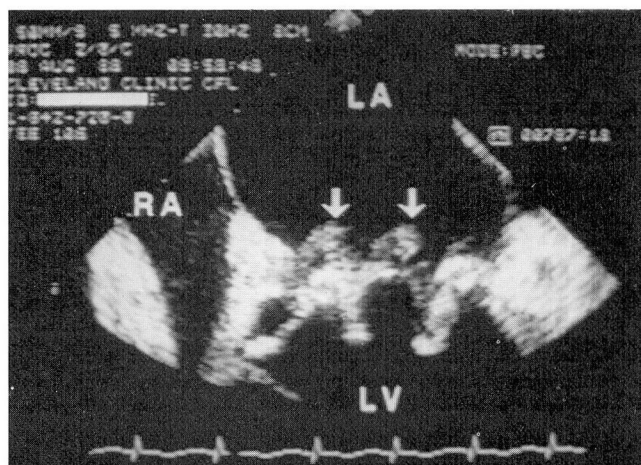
Transesophageal echocardiogram in four-chamber view shows large vegetative lesions (arrows) attached to a mitral bioprosthesis prolapsing into the left atrium (LA) during systole.
